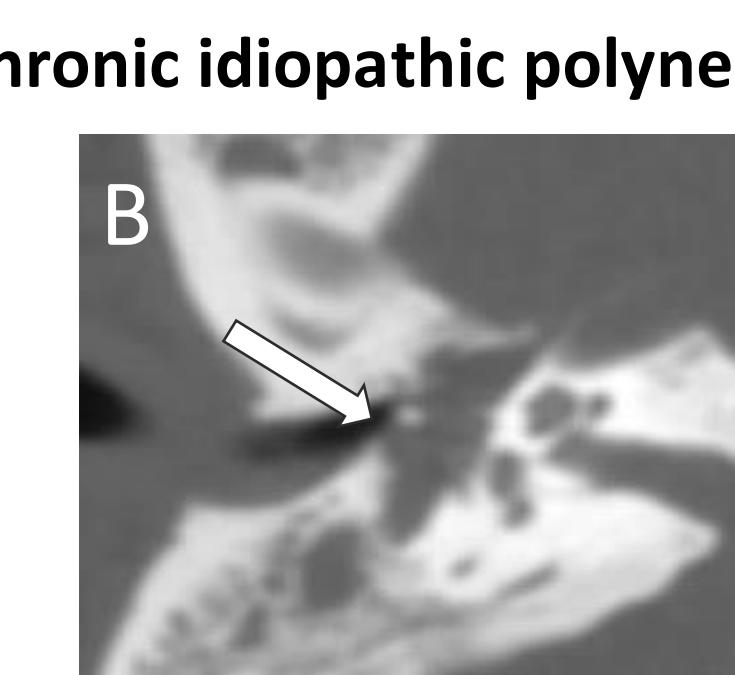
Axial CT shows remodeling and expansion of the middle ear cavity (arrow) due to enlargement of the facial nerve and chorda tympani.
